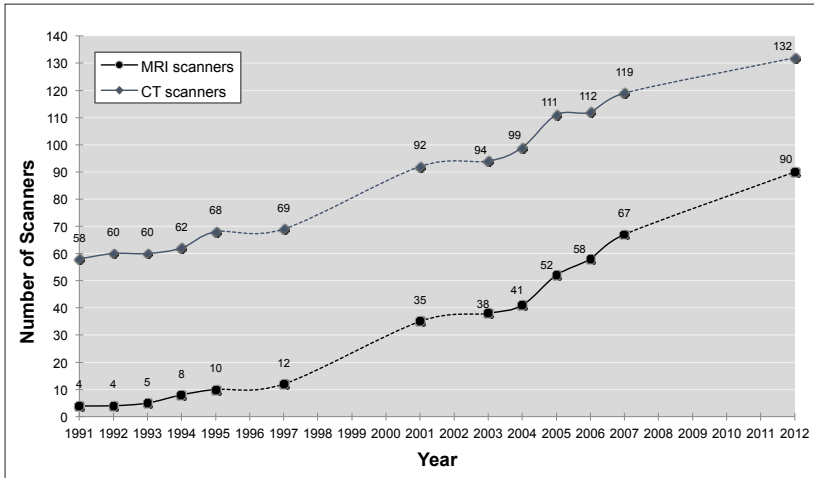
Number of MRI and CT scanners in free-standing facilities, Quebec, 1991–2012.
